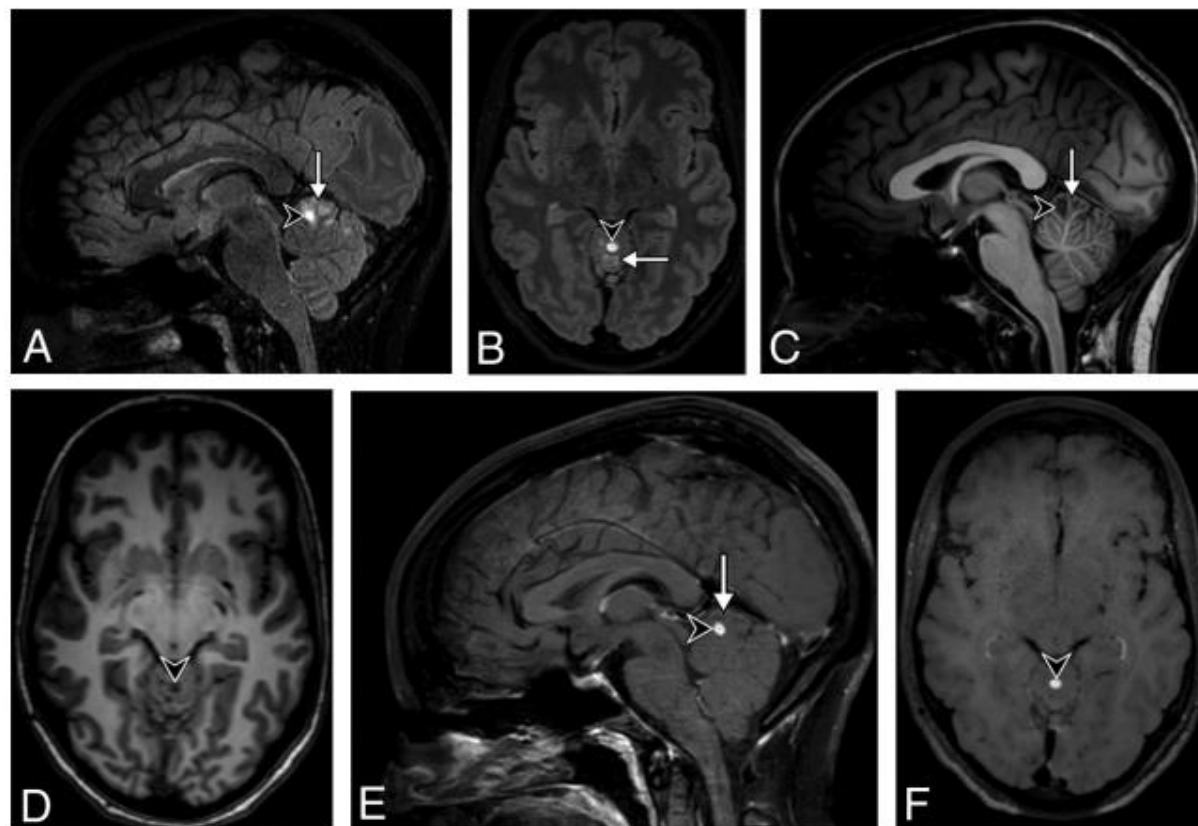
A 31-year-old woman presenting with headache. 3D-T2-FLAIR reformatted in the sagittal (A) and axial (B) planes shows a high signal intensity multinodular lesion (arrow) of the upper vermis, highly suggestive of an MV-PLUS. Almost all clustered nodules are hypointense on 3D-T1WI reformatted in the sagittal (C) and axial (D) planes and do not enhance on postcontrast 3D-T1WI reformatted in the sagittal (E) and axial (F) planes. One anterior nodule (arrowhead) shows a substantially higher T2-FLAIR and lower T1 signal intensity than all the others, with a marked enhancement after contrast injection. Note the T2-FLAIR hypointense central dot sign does not enhance on postcontrast T1WI.
